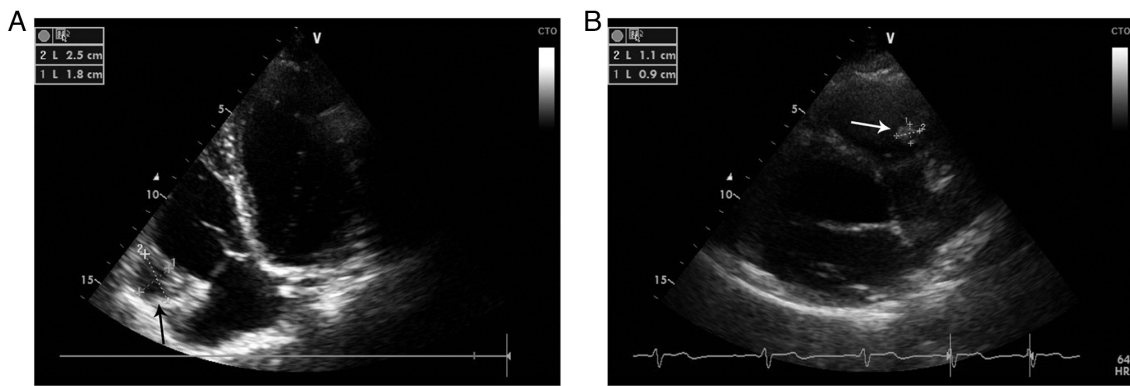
Transthoracic echocardiography presenting (A) initial presentation a slightly enlarged RV, moderate RV systolic dysfunction and a bi-lobular mass attached to the free right ventricular wall adjacent to the tricuspid valve causing no obstruction (arrow), and a (B) marked reduction in dimensions of the RV cardiac cyst and an increase of its echogenicity (1-year follow-up). RV, right ventricle.
